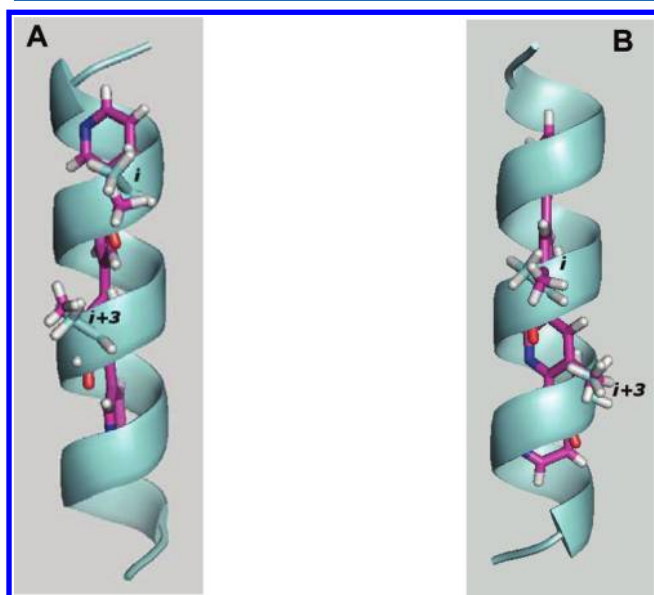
The superposition of the X-ray structure of conformer 1 of the compound 5 (A) and conformer 2 of the compound 5 (B) on an α helix.
